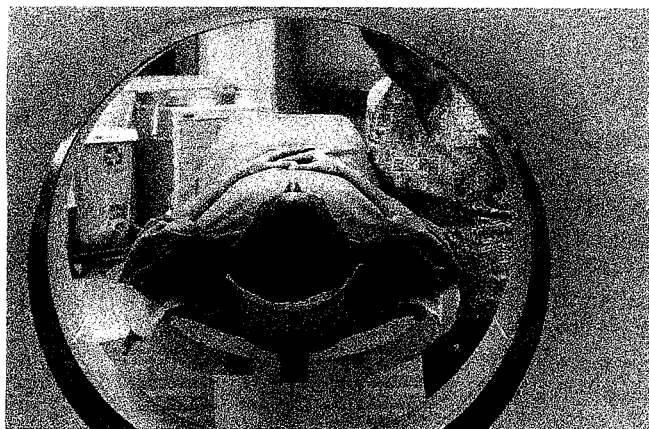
Computerized Tomography (CT) Scanner.
